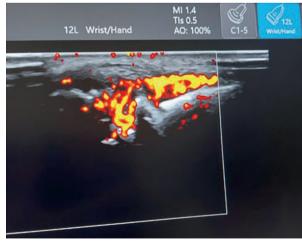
Ultrasound images of the hand and wrist with increased fluid reaction and high Doppler signal. A first compartment of extensor tendons of the wrist: Abductor Pollicis Longus and Extensor Pollicis Brevis tendons; B metacarpophalangeal joint
